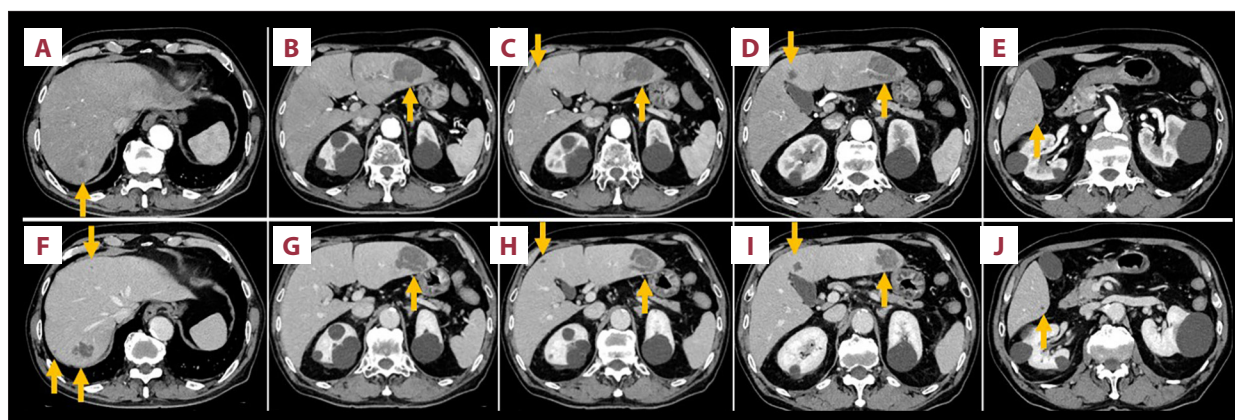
CT findings of multiple pyogenic liver abscesses. Early-phase (A-E) and delayed-phase (F-J) CT images are shown. Multiple liver abscesses (orange arrows) were mainly located in the distal liver. CT, computed tomography.
